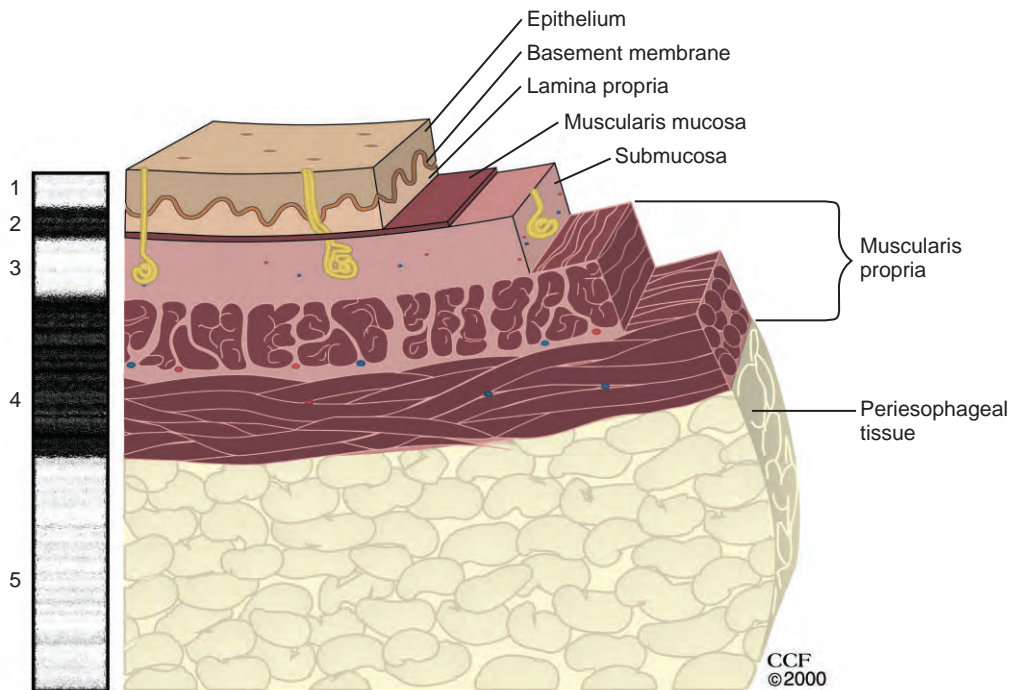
The esophageal wall is visualized as five alternating layers of differing echogenicity by esophageal ultrasound. The first layer, which is hyperechoic (white), represents the superficial mucosa (epithelium and lamina propria). The second layer, which is hypoechoic (black), represents the deep mucosa (muscularis mucosa). The third layer, which is hyperechoic (white), represents the submucosa. The fourth layer, which is hypoechoic (black), represents the muscularis propria. The fifth layer, which is hyperechoic (white) is the periesophageal tissue.
